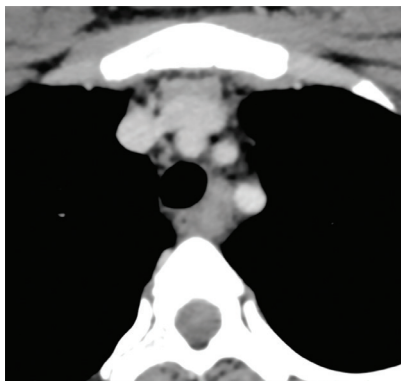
CT image of the chest showing enlarged node in left lower paratracheal region.
